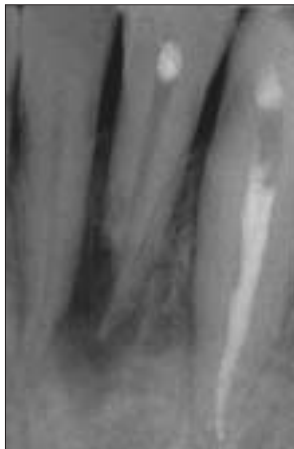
Outcome classified as “healed.” Pre-operative radiograph of a mandibular lateral incisor with apical periodontitis and associated apical external resorption.
